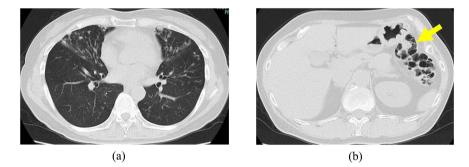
Chest CT (a) showing nodular and bronchiectatic lesions in the right middle lobe, left lingula, and left lower lung due to pulmonary MAC disease. Abdomen CT (b) showing multiple gas-filled cysts in the intestinal wall (arrow) due to PCI (Case 2).
